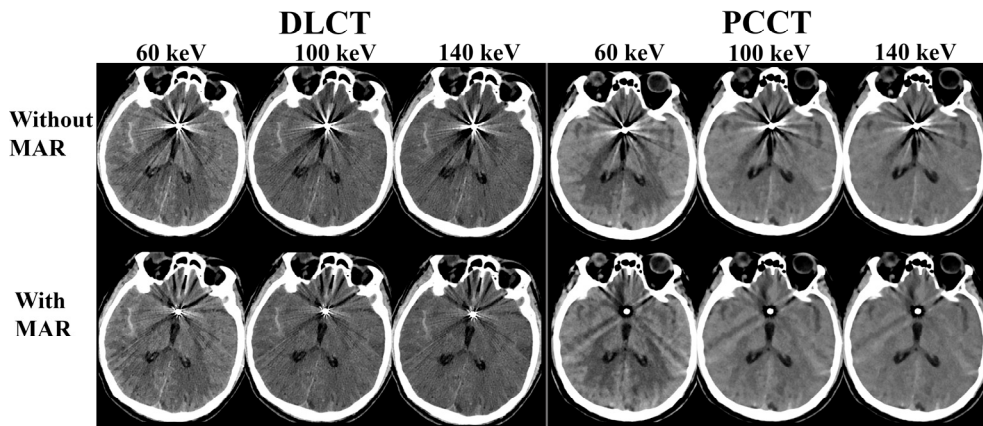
Patient images example for the dual layer computed tomography (DLCT, left) and photon counting computed tomography (PCCT, right). From left to right: monoenergetic image reconstructions at 60, 100 and 140 keV, top row without metal artifact reduction (MAR) and bottom row with MAR. Window settings were the same for both computed tomography systems (center=40, width=80). Adopted from Paper IV.
